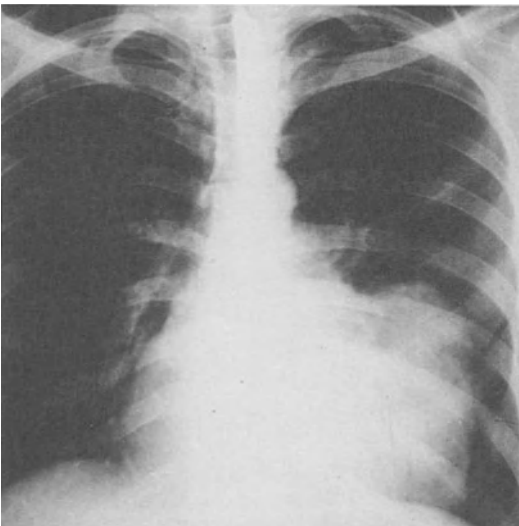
X-rays demonstrating the typical appearance of a calcified submitral aneurysm in a young African.
